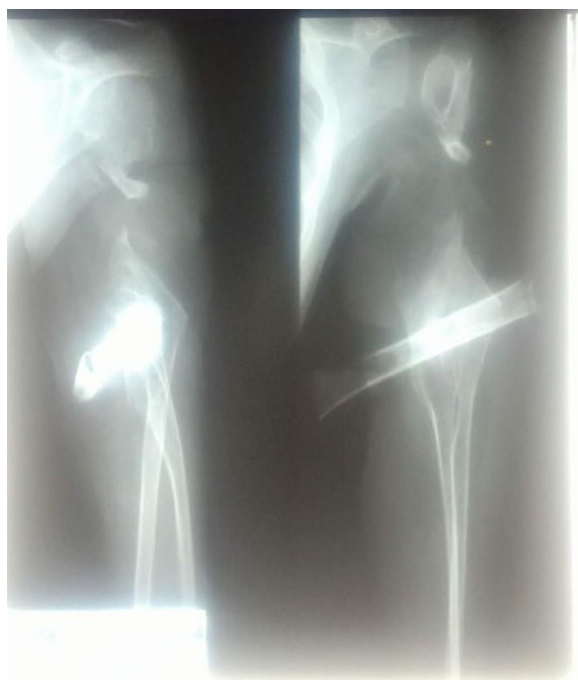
Anteroposterior and lateral X-ray films of the upper left arm. They showed a complete, transverse fragment fracture from proximal one-third to middle humerus bone which is displaced into antero-inferior with the lytic lesion and sclerotic on distal one-third humerus bone
